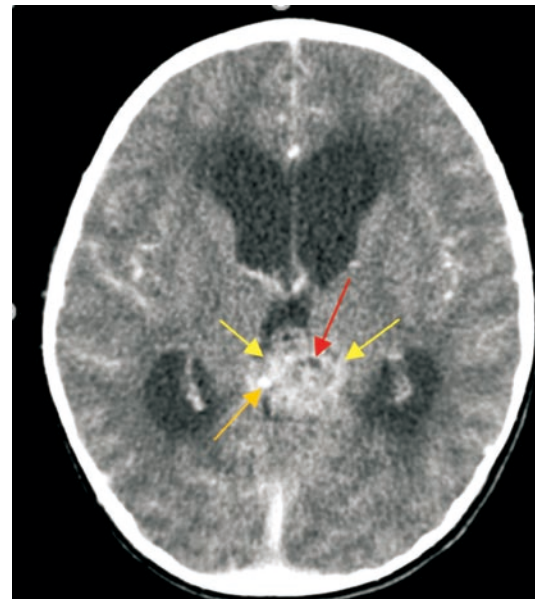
Urgent CT scan of the brain. It shows an enlargement of pineal gland causing obstructive hydrocephalus and cerebral oedema. Contrast-enhanced CT scan of the brain exhibits a heterogeneously enhancing, lobulated, mixed solid and cystic mass at pineal gland region shown by yellow arrows. Peripheral calcification is shown by orange arrows and cystic region shown by red arrow consistent with pineal teratoma. It also shows the presence of hydrocephalus and cerebral oedema evidenced by generalised effacement of the cerebral sulci.
